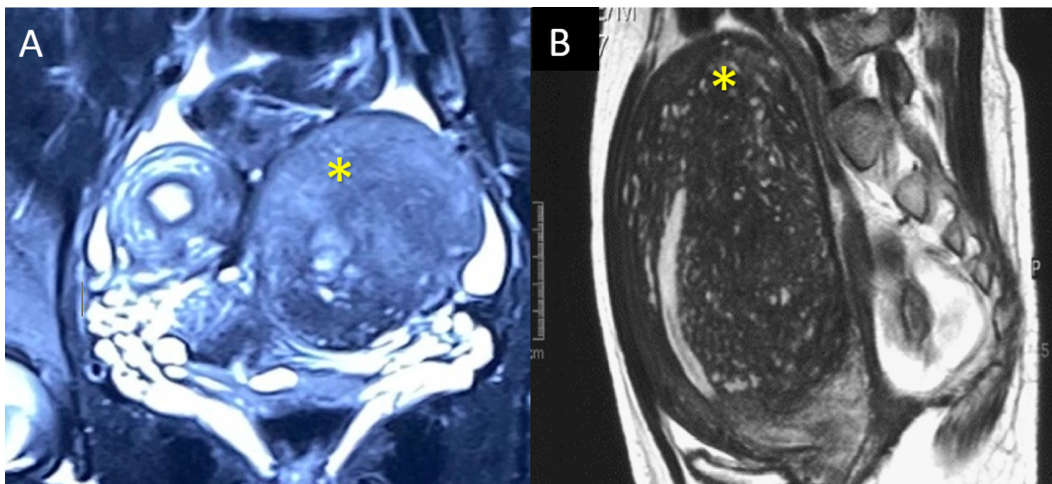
A showing coronal section of MRI imaging of a 19-year-old female with severe dysmenorrhea with bicornuate uterus and diffuse adenomyosis in the left horn (asterisk). Figure B showing sagittal section of MRI pelvis with an enlarged uterus and diffuse adenomyosis in a young nulliparous woman with infertility. Courtesy All India Institute of medical Sciences, New Delhi.
